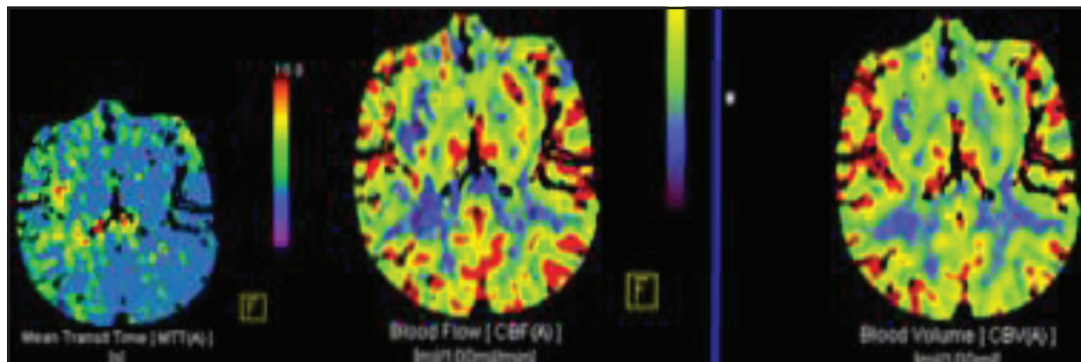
CT perfusion image showing patchy areas of decreased perfusion.
